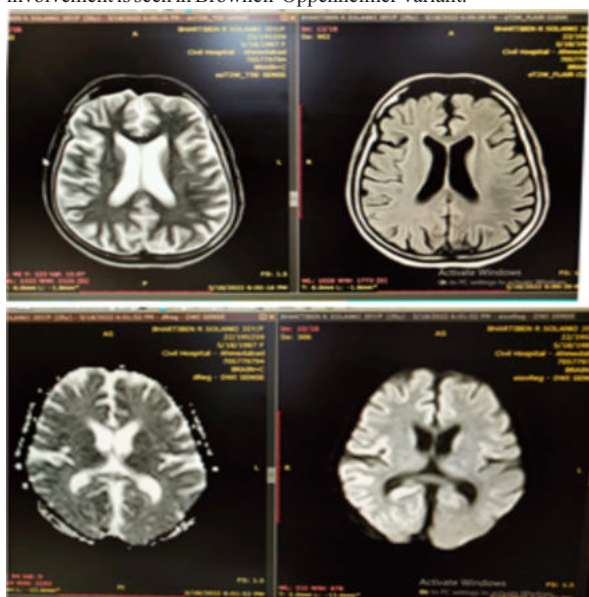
MRI Brain Of CJD Patient
